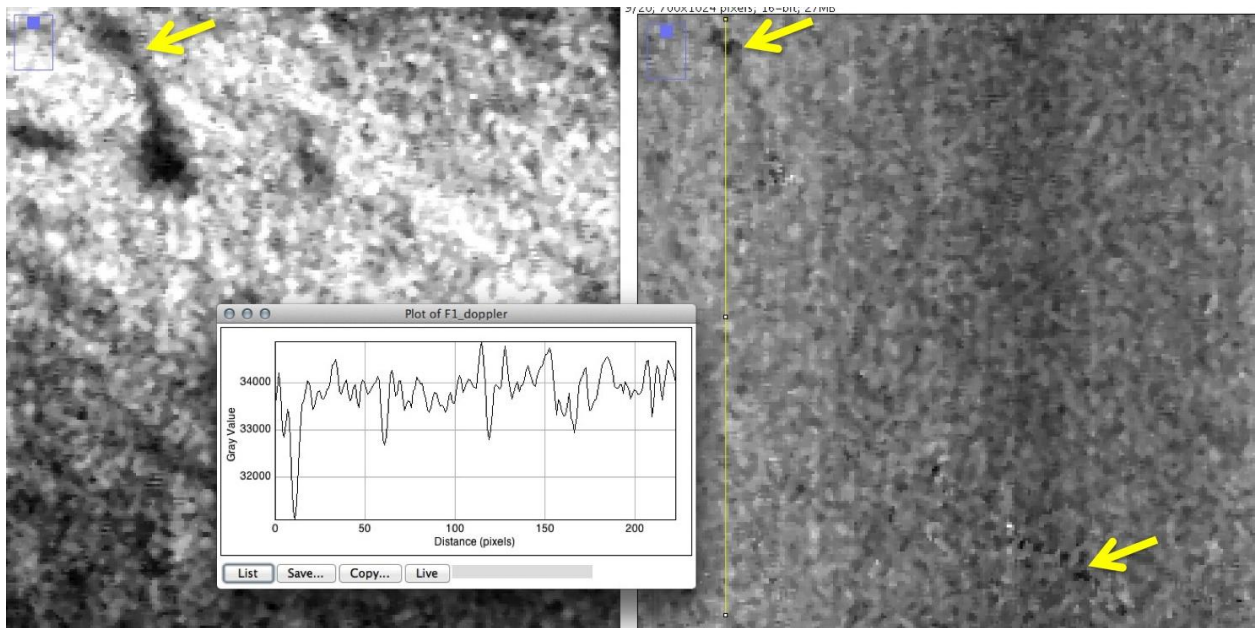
The second Doppler region signal
